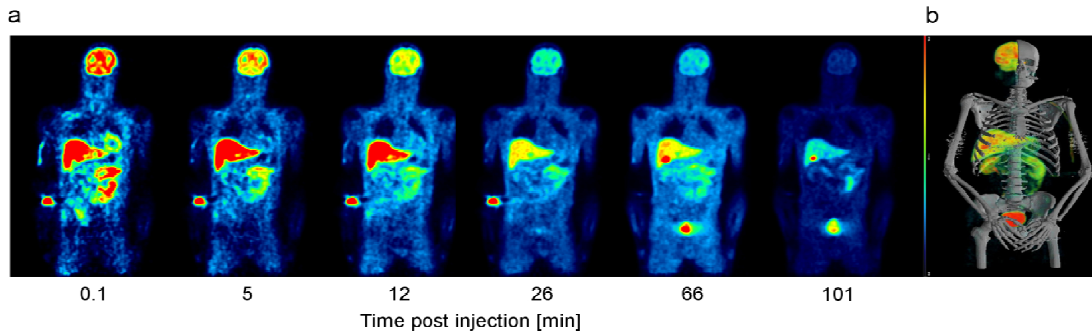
Whole body coronal image of representative subject at different time points post administration of [ $^{18}\text{F}$ ]UCB-H (same slice and activity scale, filtered with Gaussian kernel of 8 mm isotropic, injection equipment removed after fourth frame for quantification of remaining activity) and b) 3D representation of PET/CT image averaged over all frames
